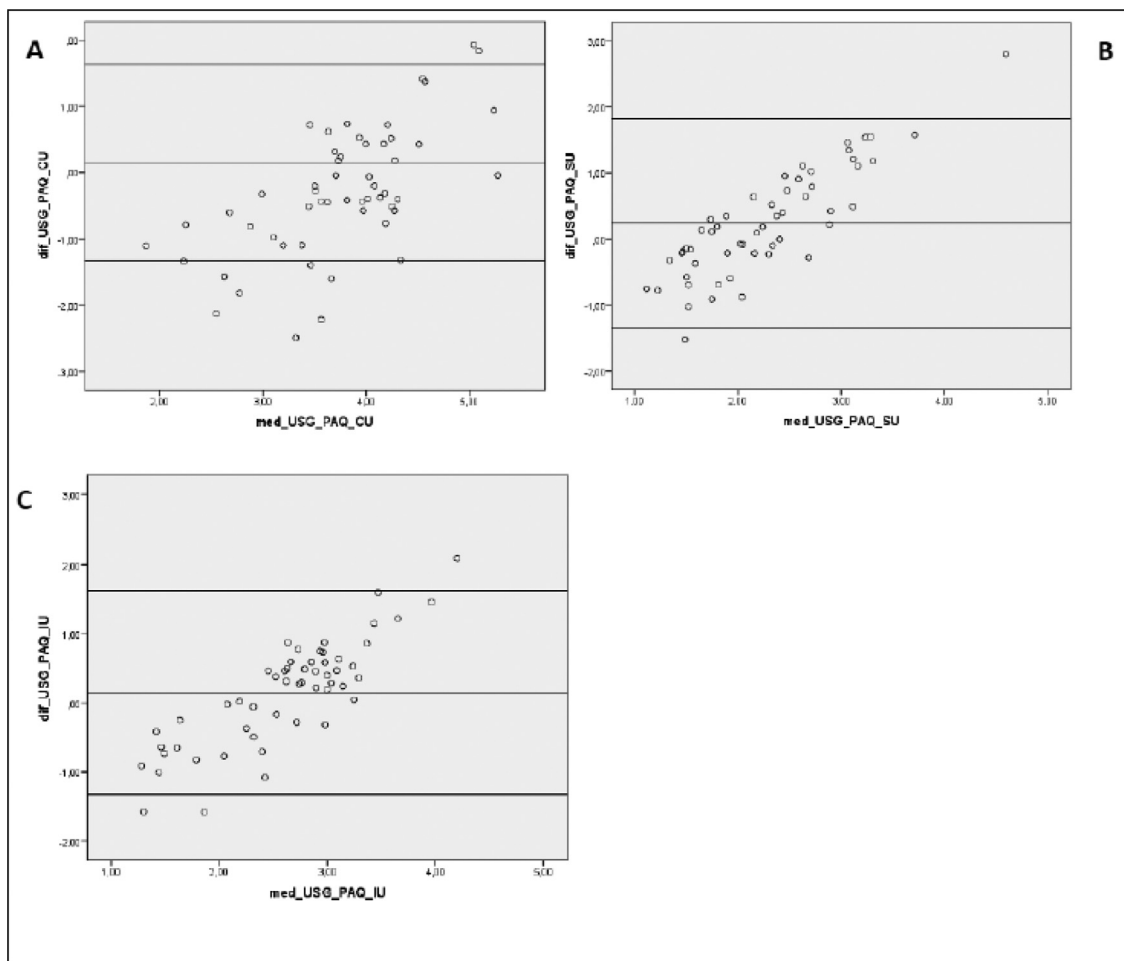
Bland-Altman plots showing the reliability of digital calipers compared with USG: (A) umbilical scar, (B) 3 cm supraumbilical, and (C) 2 cm infraumbilical point. USG, ultrasonography.
